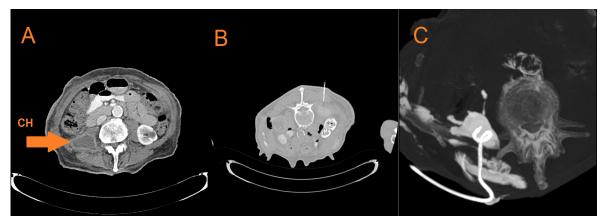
PD in Retroperitoneal Hydatid cyst. A: After the operation, the placement of the catheter into the cyst; B: Retroperitoneal hydatid cyst accessing needle CT image; C: After the PD operation, the placement of the catheter into the cyst
